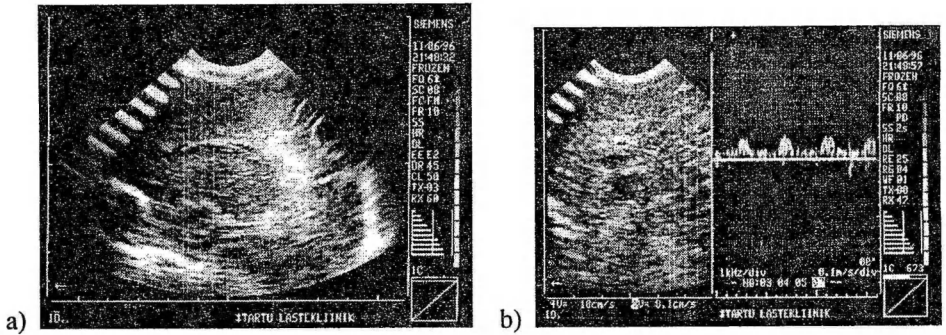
Ultrasound scans of a severely asphyxiated newborn infant with a severe stage of HIE with spastic diplegia at the age of 18 months.
